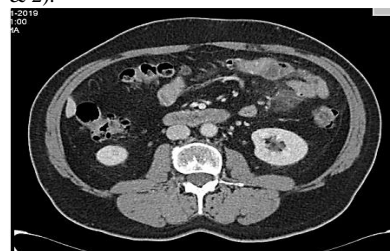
CT scan axial view showing an area of fat stranding in the vicinity of a jejunal loop that shows thickening and blurring of the wall and adjacent adenopathy's, in the region of the left flank.
